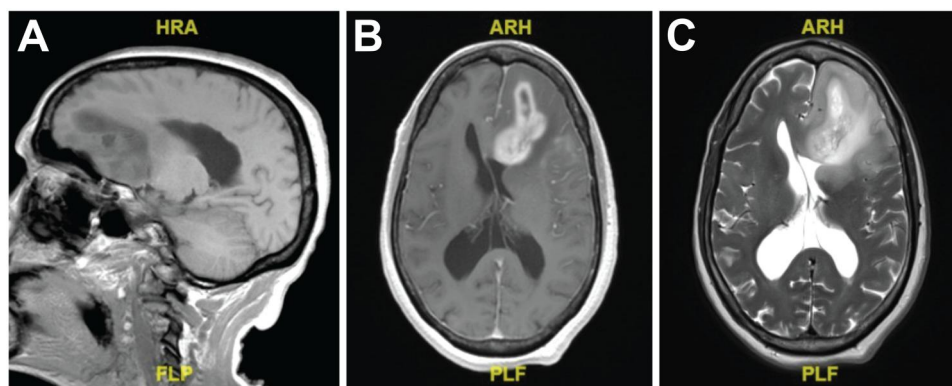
Magnetic resonance imaging of the tumor. (A) Sagittal T1-weighted image demonstrating the left frontal tumor. (B) Axial post-contrast T1-weighted image showing tumor contrast enhancement, mass effect and a left to right midline shift. (C) Axial T2-weighted image demonstrating peritumoral and edema and midline shift.
